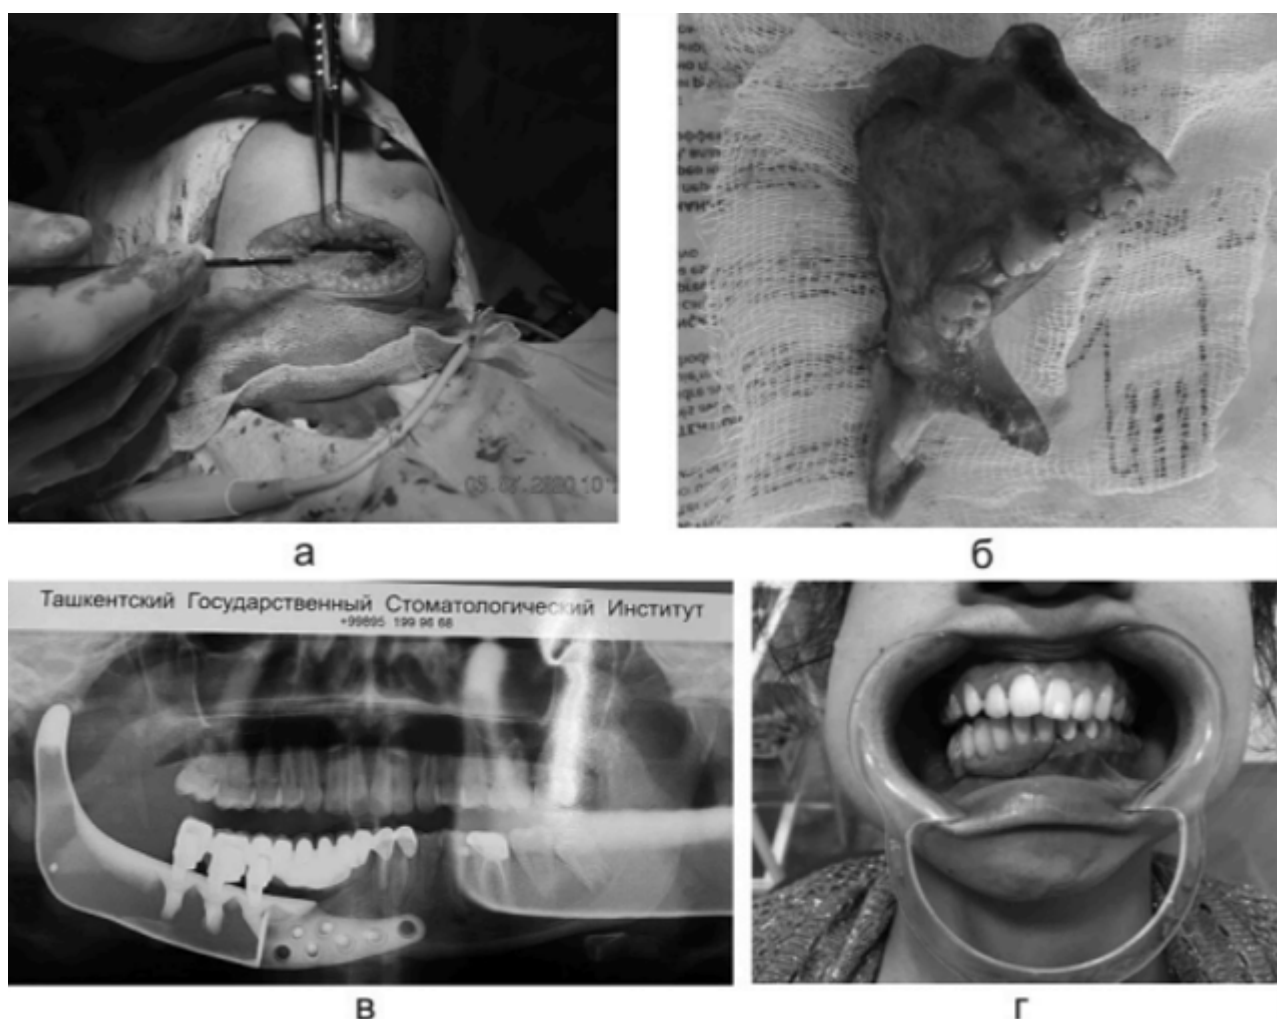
Removal of a tumor-affected fragment in the lower jaw on the right (a. progress of the operation; b. removed tumor along with a fragment of the jaw; c. orthopantomogram of a patient after surgery; d. restored dentition)
